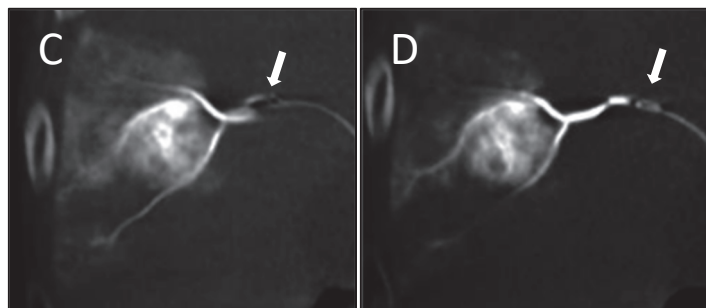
Cone Beam CT demonstrating the Sniper Balloon Catheter advanced over a 0.016" guidewire (Fathom, Boston Scientific, Natick, Massachusetts) and deployed in the right hepatic artery. Image C shows the Sniper Balloon deflated (white arrow) while image D shows the Sniper Balloon inflated (white arrow), resulting in increased specificity of tumor blush and decreased surrounding parenchymal enhancement.
